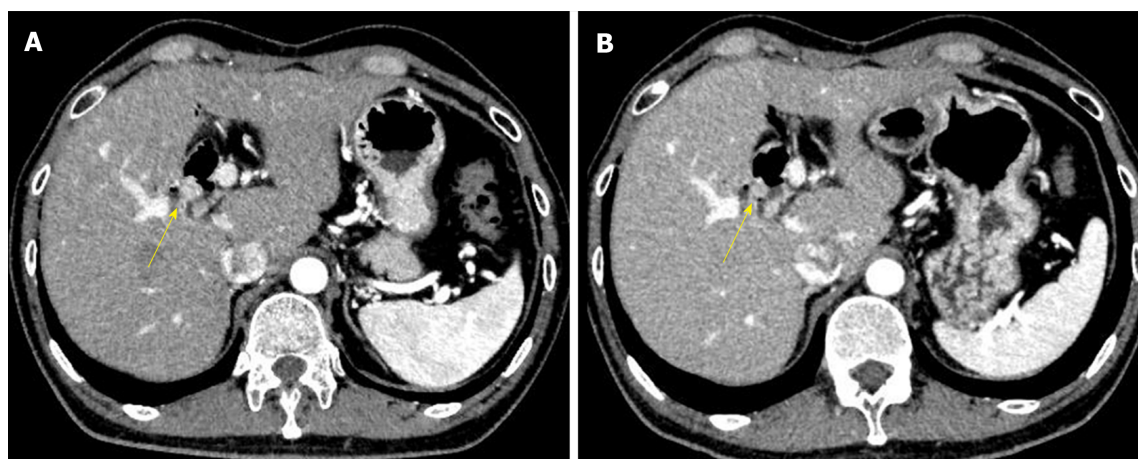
Abdominal CT images with contrast. A: Five and a half years after his first operation; B: Six years after his first operation. The images show a gradually growing nodule with contrast over a half a year (yellow arrow).
